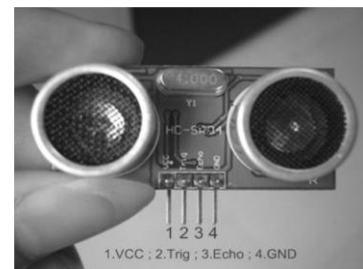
Image of the HC-SR04 Ultrasonic Sensor (EF03085 HC-SR04 User Guide)
